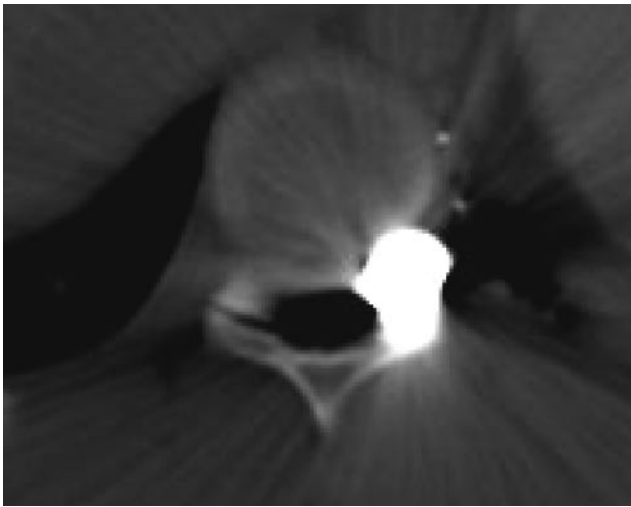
Computed tomography image shows fragment in T10–T11 neuroforamen.
